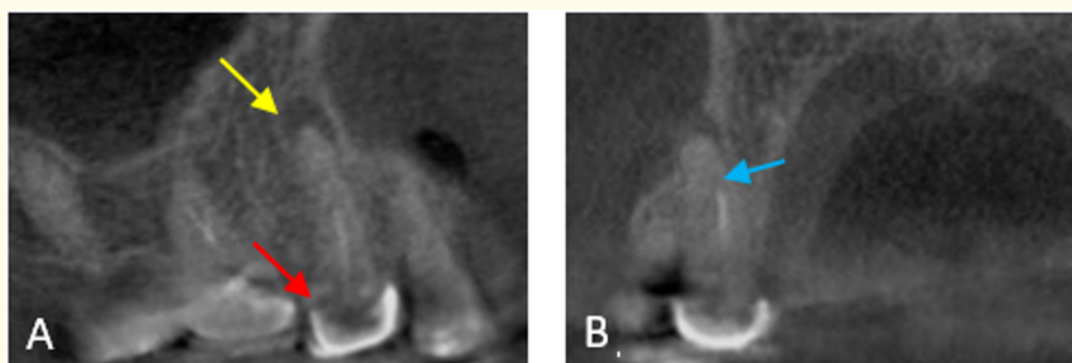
Cone beam computed topography tooth #15. (A) Sagittal view, (B) Coronal view both showed tooth #15 with periapical radiolucency (yellow arrow). The tooth has short root canal filling (blue arrow), also open gap was noticed in the crown (red arrow).
